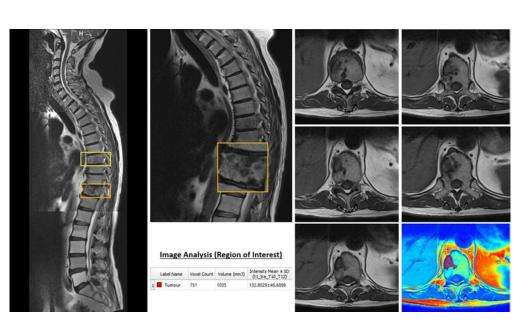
Example MRI image acquisition. [Left]: cervical, thoracic and lumbar scout views stitched together with two sclerotic lesions identified at T8 and T11. [Top, Middle]: thoracic scout view at higher resolution with the T11 vertebrae magnified. [Bottom, Middle]: example data outputs provided by regional analysis. [Right] slice by slice, cephalad to caudal, transverse view at each level of the T11 lesion, with an example colour map and tumoural analysis of one slice in isolation.
